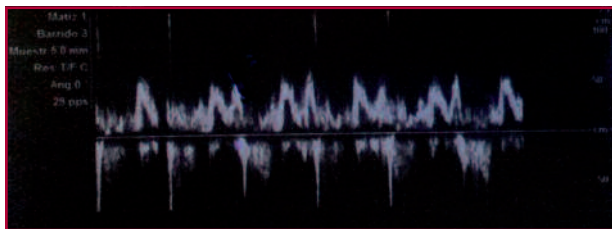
First transthoracic echocardiography - Mitral flow.
